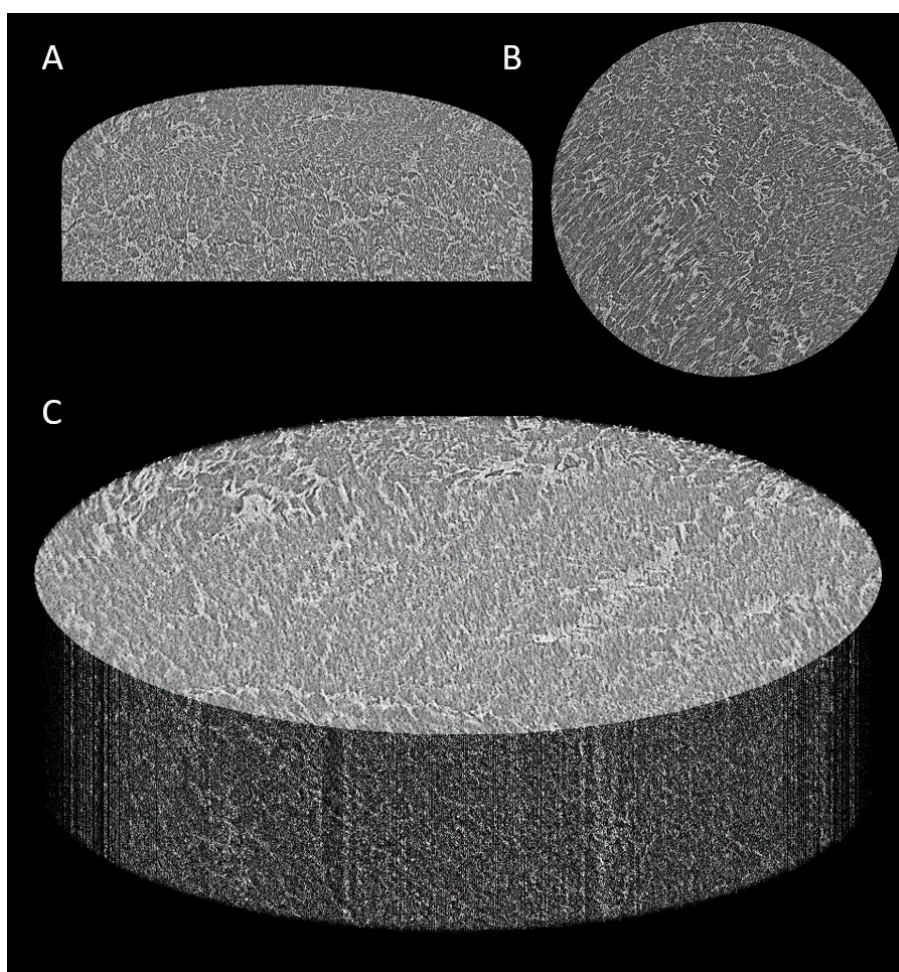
Micro CT scans of a 5% PVA aerogel showing (a) a three-dimensional representation of an orthogonal slice through the scanned section (b) a cross section of the scanned section of the gel and (c) a full three-dimensional representation of the scanned portion of the gel.
